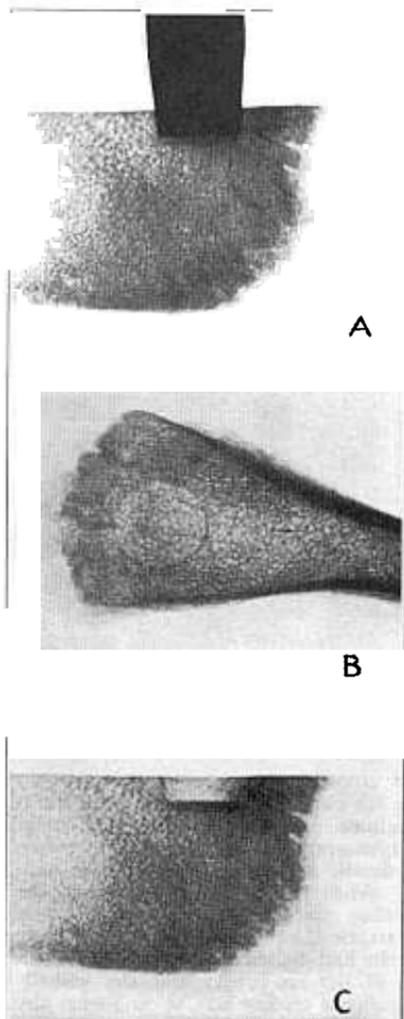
Limitations of roentgen-ray to disclose chamber in bone: *A*, square end punch in position; *B*, perpendicular roentgenographic appearance of chamber; *C*, right angle appearance of chamber. A zone of condensed bone obstructs the view in *B*.
